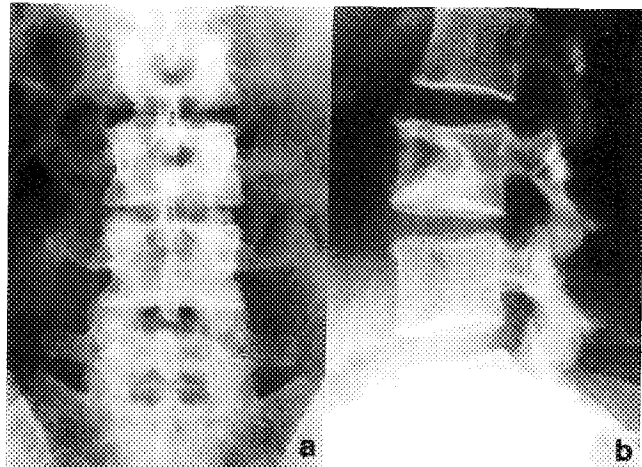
Radiograph of lumbar spine; monostotic fibrous dysplasia L<sub>3</sub>. See description in text.
